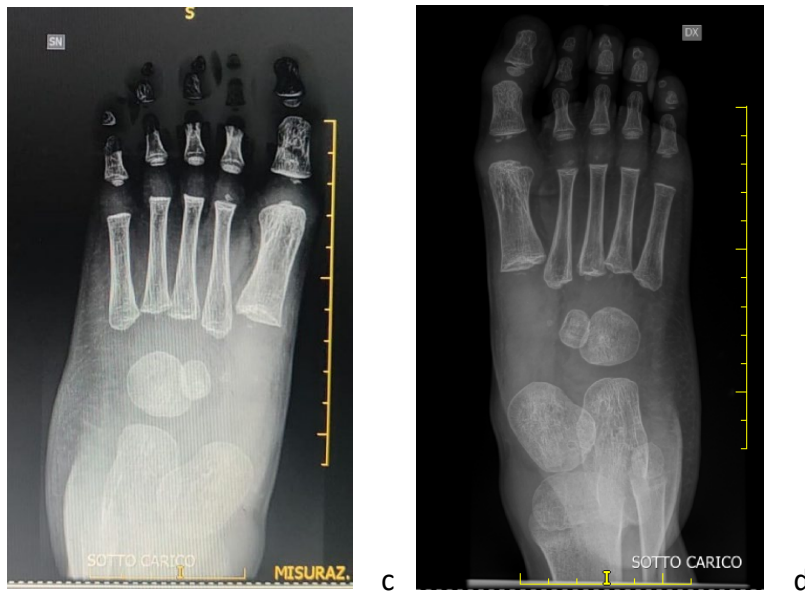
Weight-bearing X-rays: LL view of the right (a) and left (b) foot; AP view of the right (c) and left (d) foot
